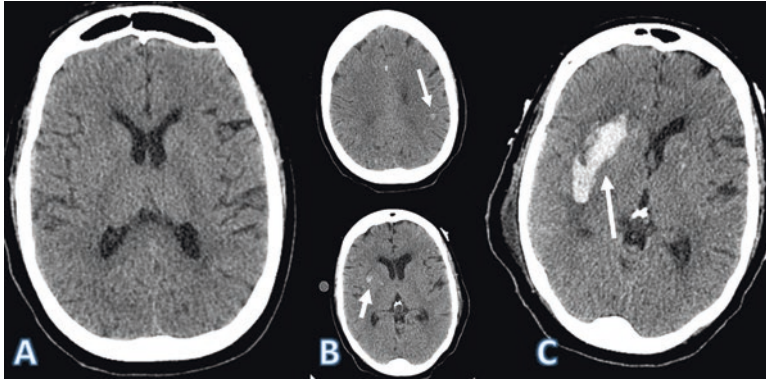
A COVID-19 patient with severe respiratory distress on ECMO. Axial baseline brain CT shows mild microvascular disease; otherwise, no acute intracranial lesion (a). Follow-up CT 2 days later shows tiny new foci
